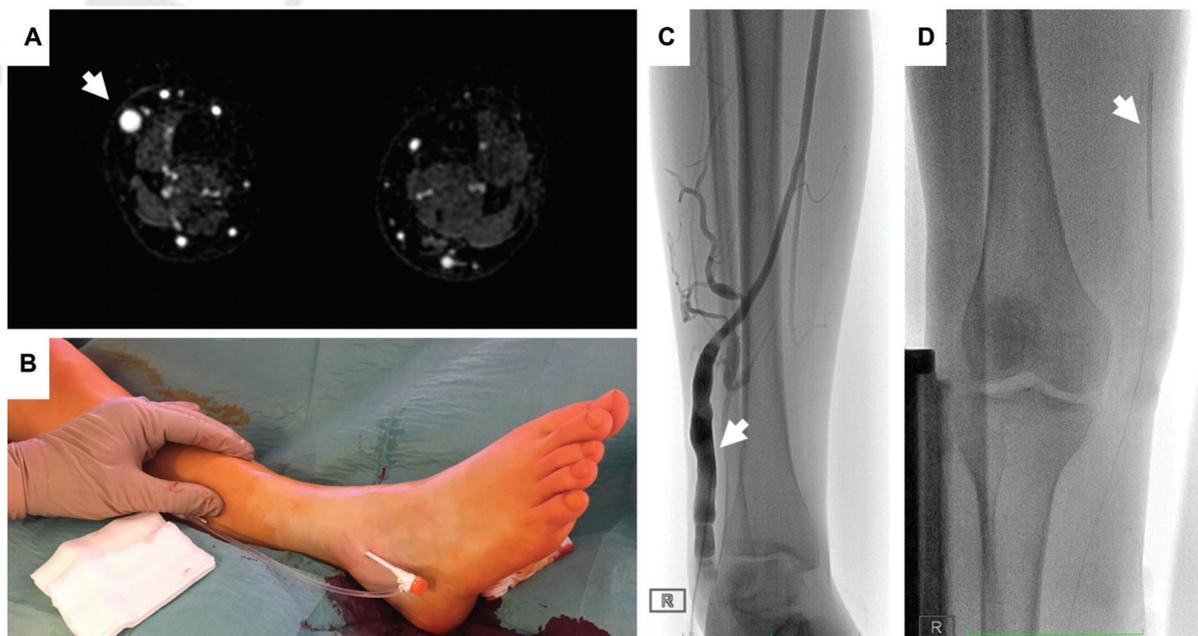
Radiofrequency ablation (RFA) of marginal vein (MV) of the right leg in an adolescent girl. (A) Dynamic contrast-enhanced MRI shows MV (arrow) coursing along the lateral aspect of the right calf. (B) Peri-interventional setting with 7-F introducer sheath inserted in the distal aspect of the MV. (C) Phlebography showing the ectatic MV (arrow) in the lateral aspect of the lower limb before endovenous RFA. (D) RFA catheter (arrow) is placed in the proximal aspects of the MV.
